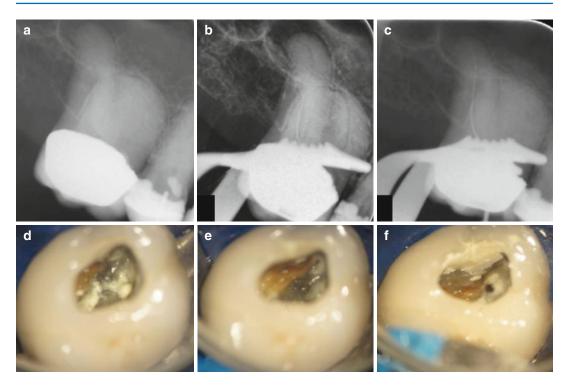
Showing clinical photographs of access refinement using ultrasonics in tooth 36. Note (a) highly calcified root canal system with (b) multiple pulp stones which
